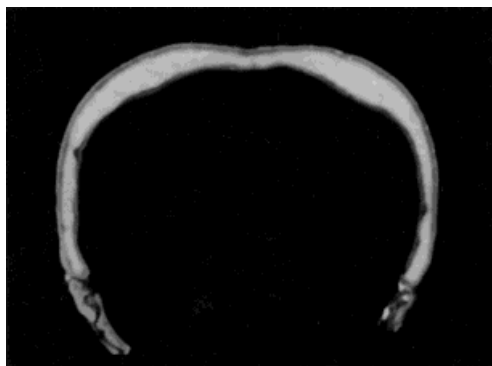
Coronal CT scans of the Singa calvaria at the level of maximum parietal bossing, as indicated in Fig. 1. Note that the scan plane is not entirely perpendicular to the external surface, but this does not affect the relative proportions of the tables.
